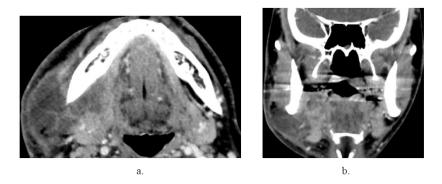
(case 10). Submandibular abscess in a 37-year-old male patient. (a) Axial and (b) coronal contrast-enhanced neck computed tomography examination demonstrating peripherally enhanced collection view with axial images starting from the submandibular region in the right half of the neck and extending along the mandible.
